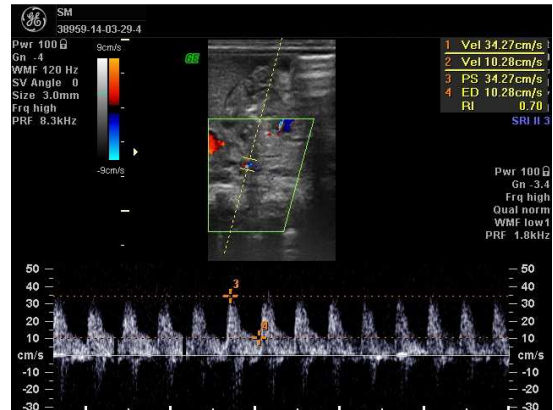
Color Doppler examination of the SMA flow indices in a neonate aged 32 weeks who did not develop NEC (PSV 34 cm/s, EDV 10 cm/s, RI 0.7, PI .86)
